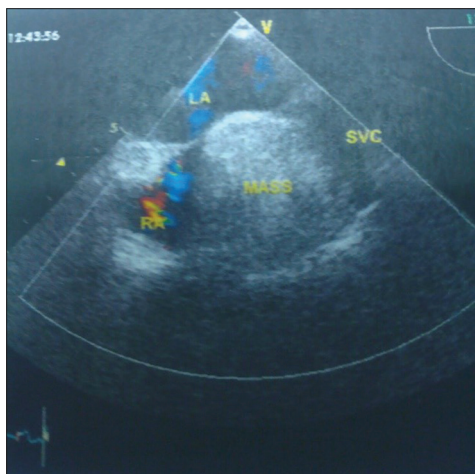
Transthoracic echocardiography study: large mass arising from atrial septum and sparing fossa ovalis (RA: right atrium, LA: left atrium)
